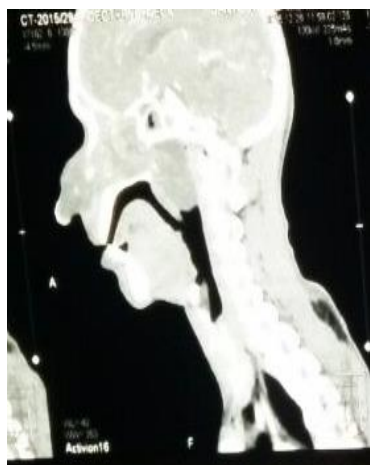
Sagittal Section of CT PNS showing hypodense lesion extending to nasopharynx
